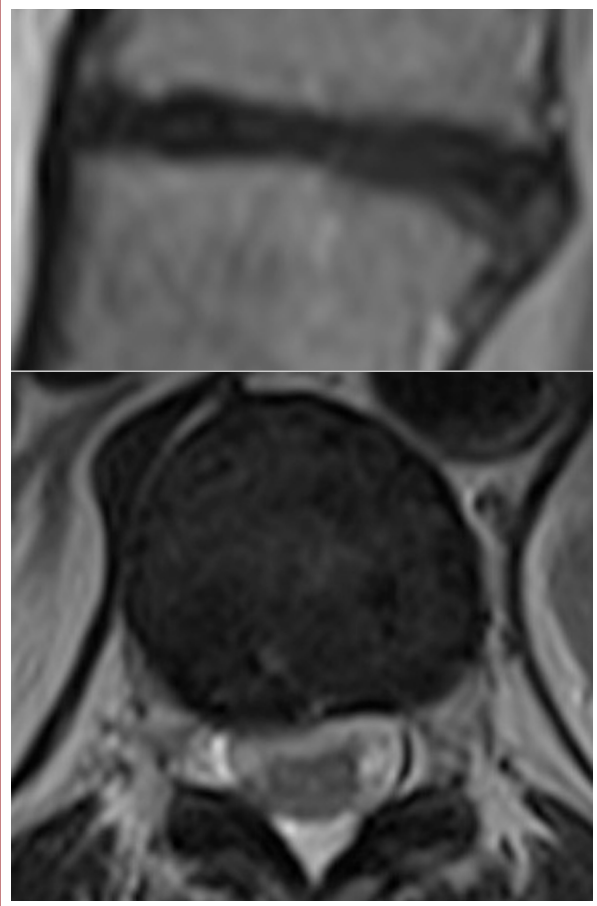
a) Grade 5 degeneration of T11–12 disc of a 53-year-old female patient in a T2-weighted sagittal image, b) in axial image, right paracentral zone- and broad-based minimal disc protrusion is seen at the same level.
